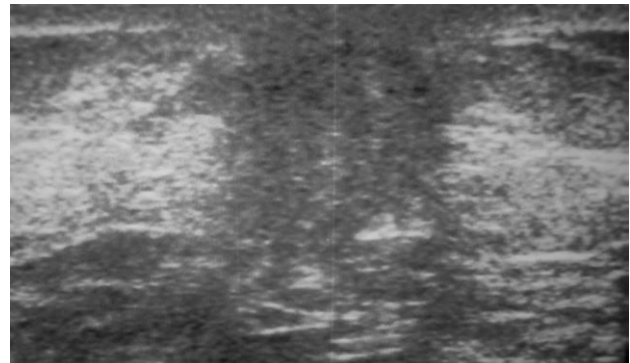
55-year-old male patient breast sonography; appearance of hypoechoic surrounded by hyperechoic area (mixed type gynecomastia).
